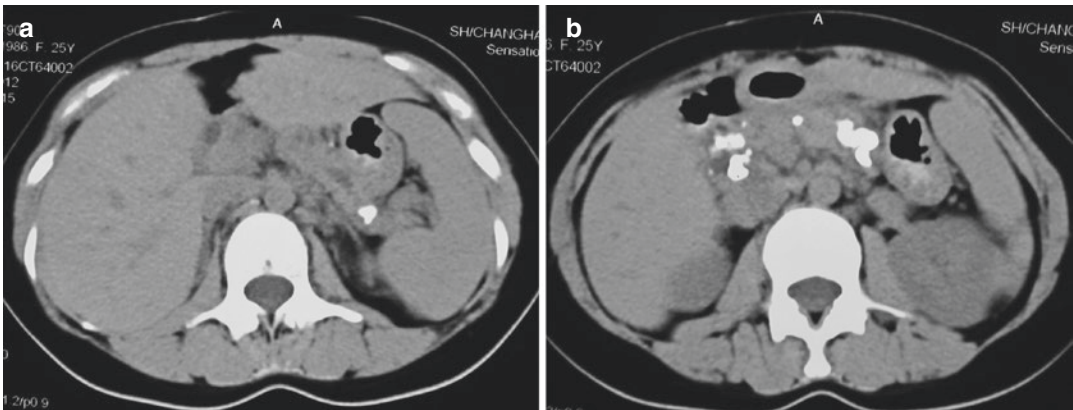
CT in our hospital revealed fewer patchy high-density shadows in the pancreas and no visualization of the gallbladder
